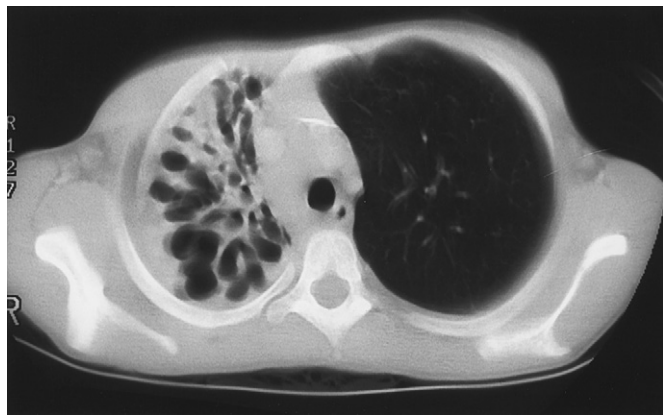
Computed tomographic scan of the chest of a 10-year-old girl with cystic fibrosis. Preoperative ventilation-perfusion scanning revealed no function of this bronchiectatic lobe. The patient underwent an upper lobectomy.
